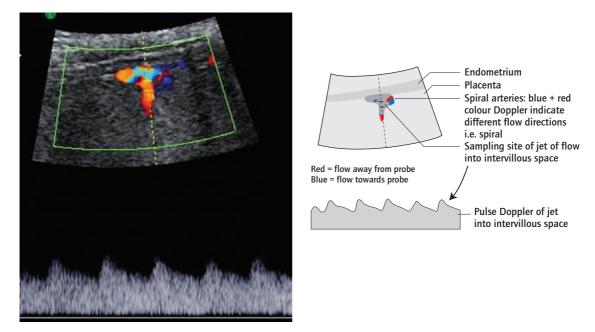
Ultrasound of the maternal-placental interface. Red: flow away from probe; blue: flow towards probe.
